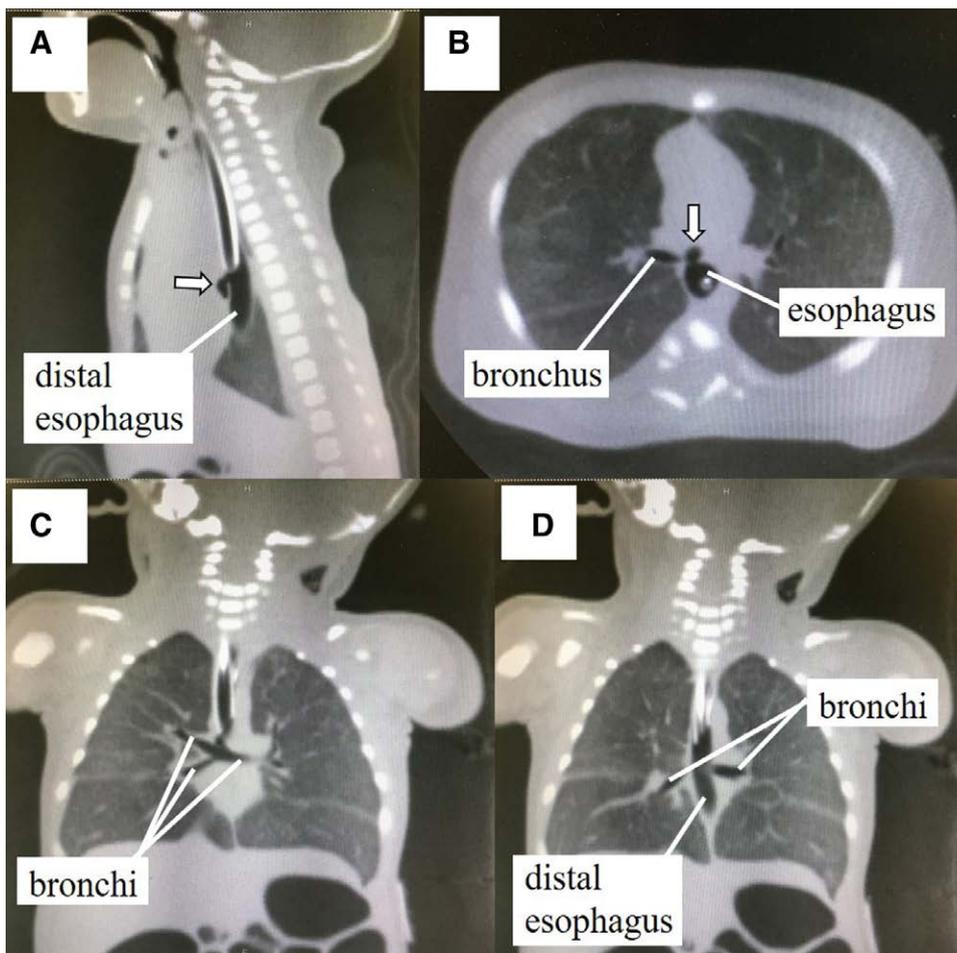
Findings of emergency CT scan. A, The sagittal section showing the ETT, which has been inserted into the esophagus and the TEF (arrow). B, The horizontal section showing TEF (arrow). C and D, The coronal sections showing the left and right bronchi branched from the TEF. The CT scan also shows abnormality of the lung lobes. CT indicates computed tomography; ETT, endotracheal tube; TEF, tracheoesophageal fistula.
